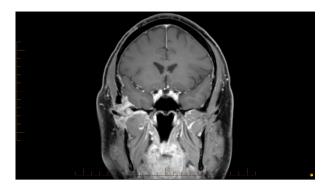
Postgadolinium magnetic resonance imaging demonstrating a lobulated mass at the inferomedial border of the previous resection.
